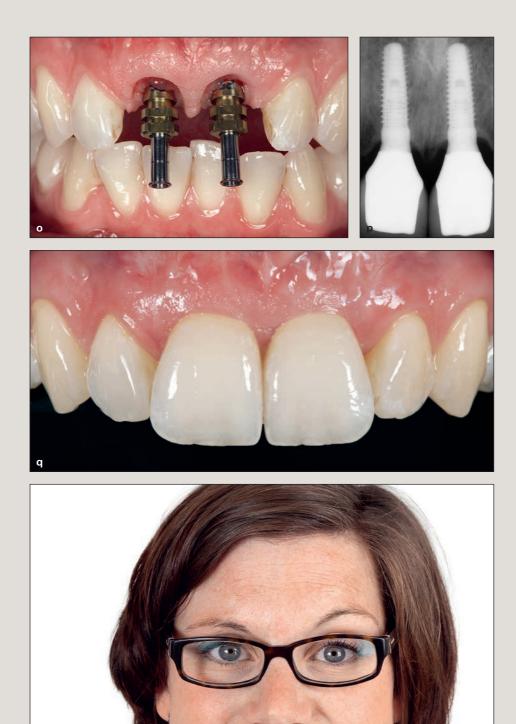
cont.* / (*o*) Taking impressions of the implants. (*p*) Radiograph of the superstructure 1 year after implant placement. Note the height of the interimplant bone, which is very important for supporting the papillae. (*q*) All-ceramic crowns 1 year after implant placement. (*r*) Portrait after completion of the treatment. (Surgery performed by A. Happe; prosthodontics performed by B. van den Bosch; laboratory work performed by A. Nolte.)
